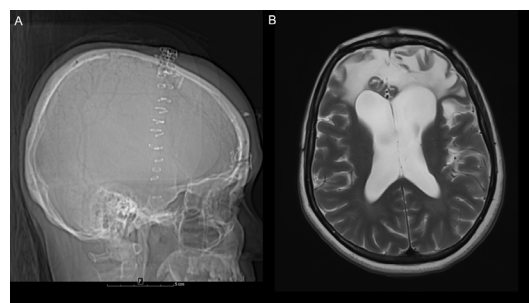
(A) Lateral skull X-ray postoperatively after total removal of the meningioma. (B) Axial T2 brain MRI showing total removal of the tumour with frontal encephalomalacia and mild compensating dilation of the anterior horn of lateral ventricle.
